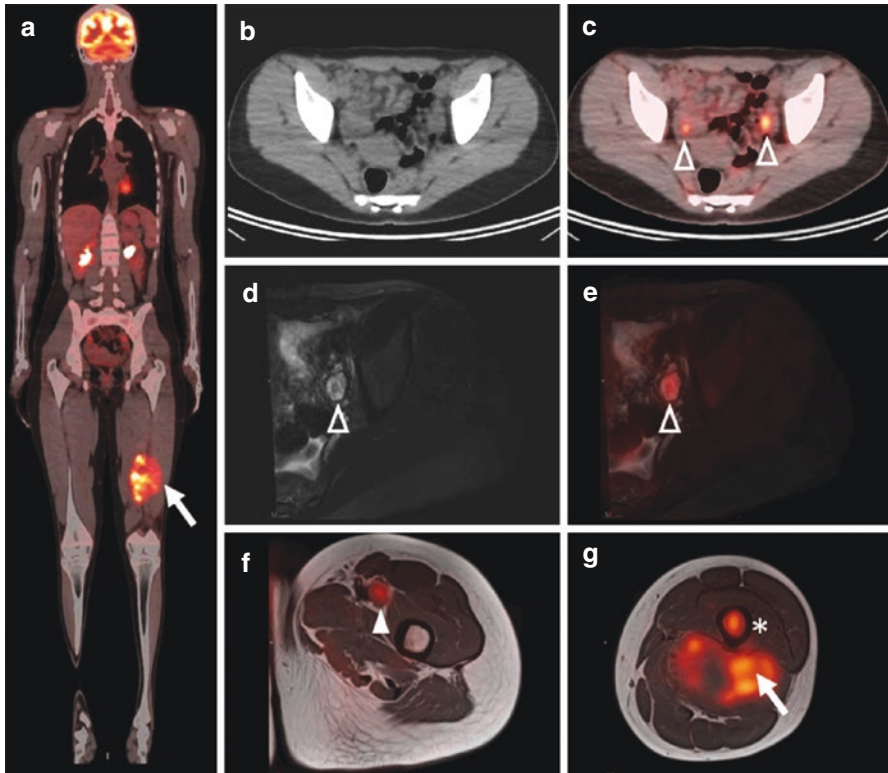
FDG-PET/MRI performed in a 14-year-old girl with extra-osseous Ewing's sarcoma. Whole body FDG-PET/CT demonstrates FDG-avid left posterior thigh mass (a, *white arrow*) and bilateral foci of FDG-uptake in the pelvis (c, *arrowhead*), which was wrongly diagnosed as bilateral external iliac lymphadenopathy on PET/CT. MRI of the pelvis and left lower extremity demonstrates normal ovary (d and e, *open arrow head*) which corresponded to the focus of increased uptake on FDG-PET/CT. Fused sequential FDG PET and MRI show a left femoral FDG-avid regional lymph node (f, *white arrow head*) and the hypermetabolic extra-osseous mass (g, *white arrow*) with bone marrow infiltration (g, *asterisk*). (a) whole body FDG-PET/CT; (b) CT of FDG-PET/CT; (c) Fused FDG-PET/CT; (d) T2 weighted images; (e–g) fused FDG-PET with T2 and T1-weighted images (f, g)
